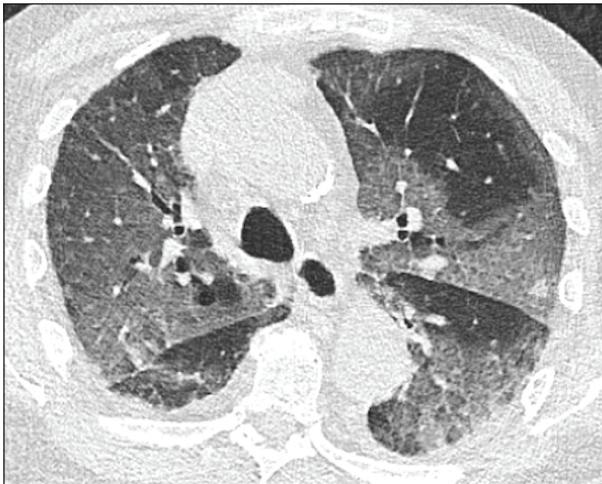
81-year-old man patient with fever, cough and respiratory failure (RT-PCR test positive): the axial image of chest CT shows multiple bilateral ground-glass areas with marked interlobular septal thickening.
